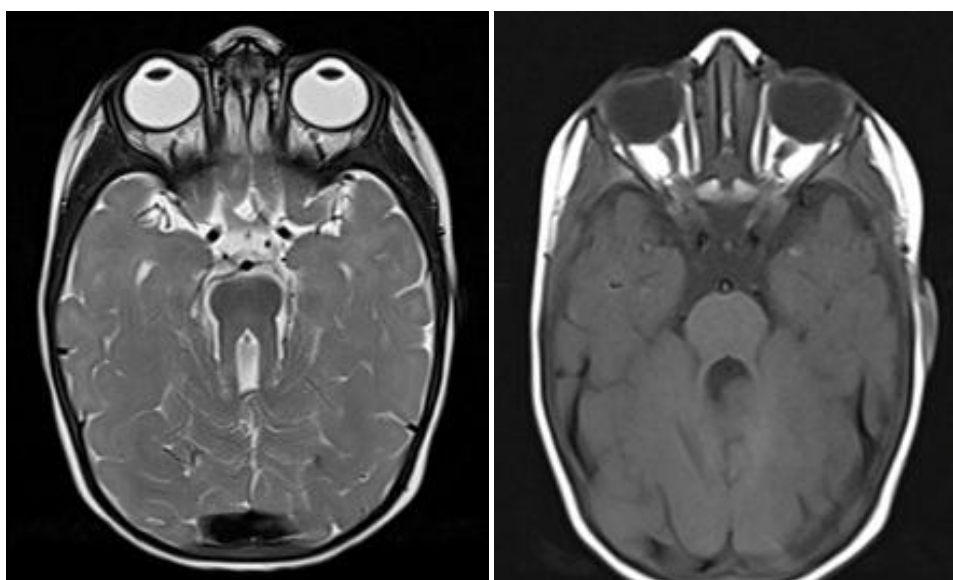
Axial section MR images showing “Molar tooth” appearance of midbrain and “Bat wing” configuration of fourth ventricle.
